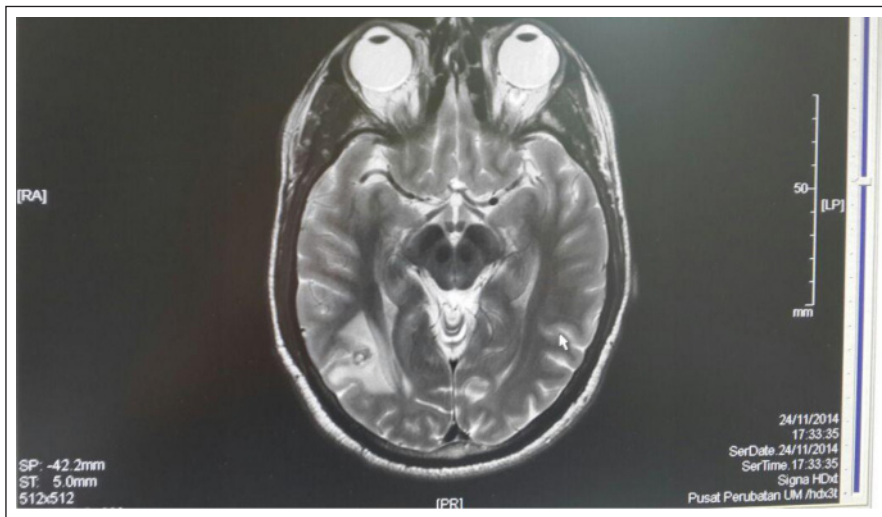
MRI brain indicating colloidal vesicular stage of the cyst, which is the first stage of involution of cysticerci. Cyst fluid is hyperattenuating to cranial spinal fluid (CSF).
